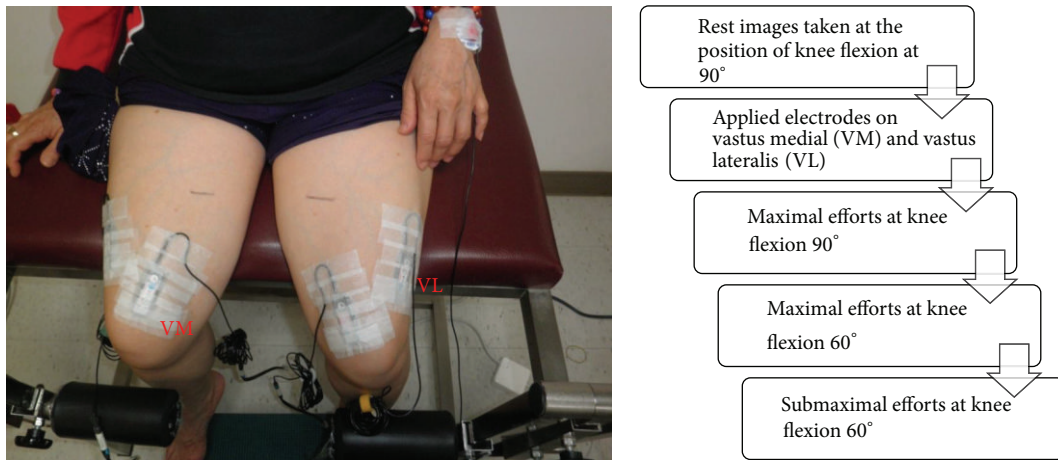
Examples of electrode positions for VM and VL placement. The ultrasound and s-EMG data is synchronously collected. The experimental protocol is listed, right.
